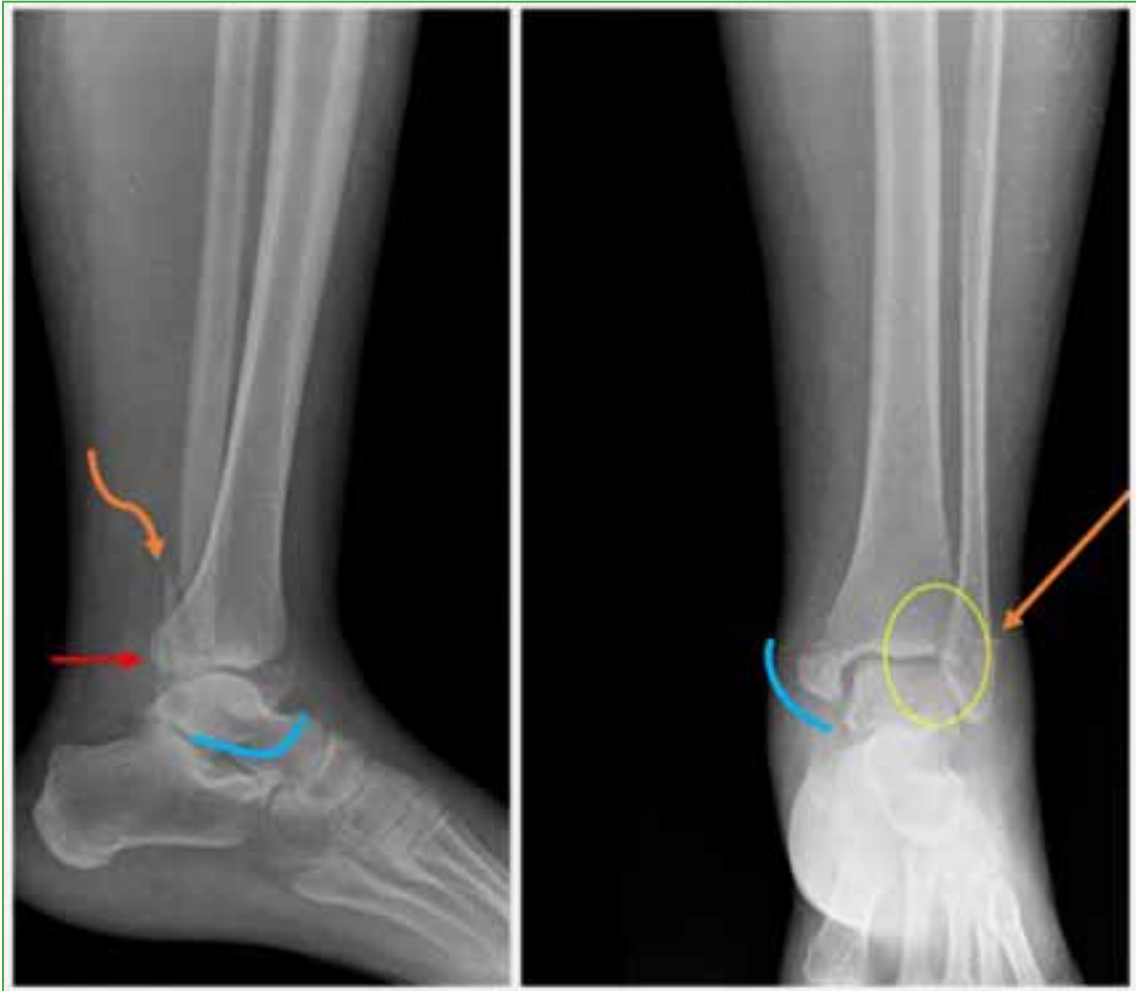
Initial lateral and anteroposterior radiographs of the left ankle. Fracture of fibula (orange arrow), fracture of the medial malleolus (blue curve), fracture of the posterior malleolus (red arrow) and lateralization of the talus (yellow oval).
